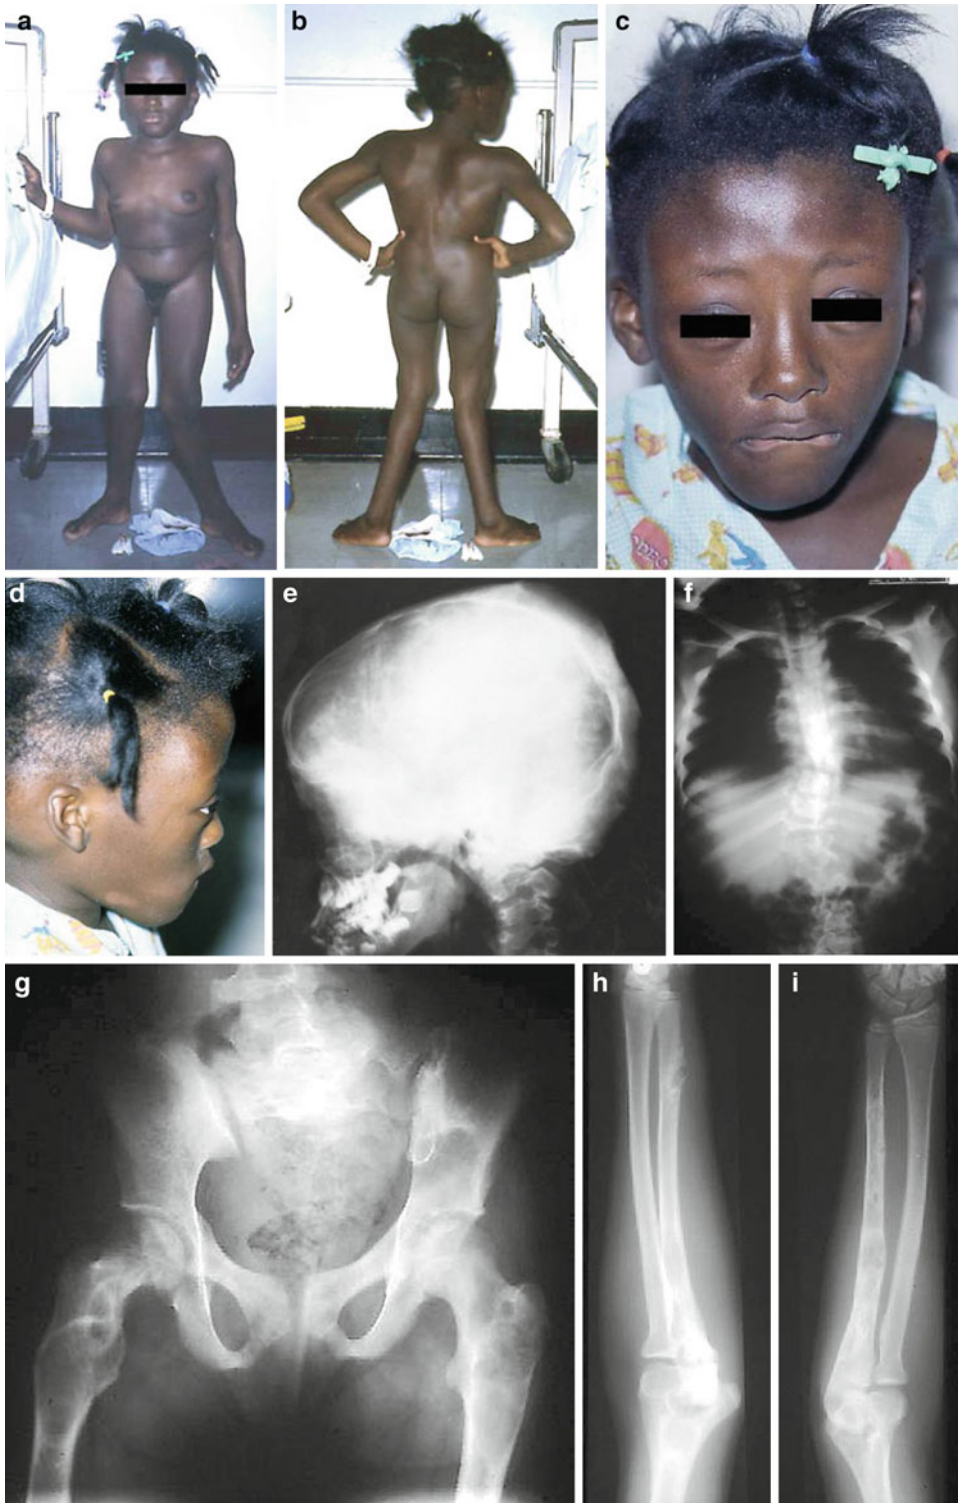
(a–i) A girl with McCune-Albright syndrome showing precocious puberty, hyperpigmentation, and fibrous dysplasia affecting many bones shown by radiographs
